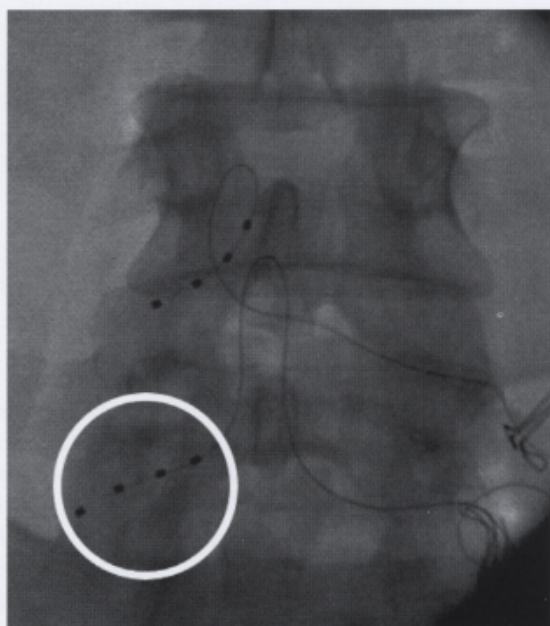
X-ray of DRG stimulation leads epidurally placed on the patient's left L4 and L5 DRGs. Only the L5 lead is in use as the L4 lead gives similar coverage.
